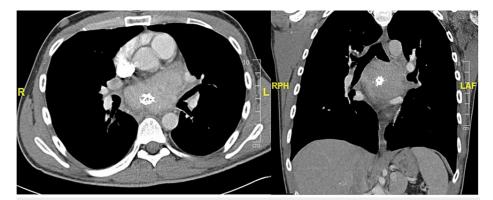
Chest CT demonstrating large mediastinal mass measuring 8.2 cm.
